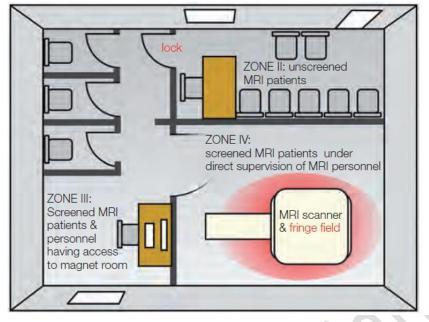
The zoning recommended by the American College of Radiology White Paper on MRI safety. Note that there has to be locked access between Zones II and III.
